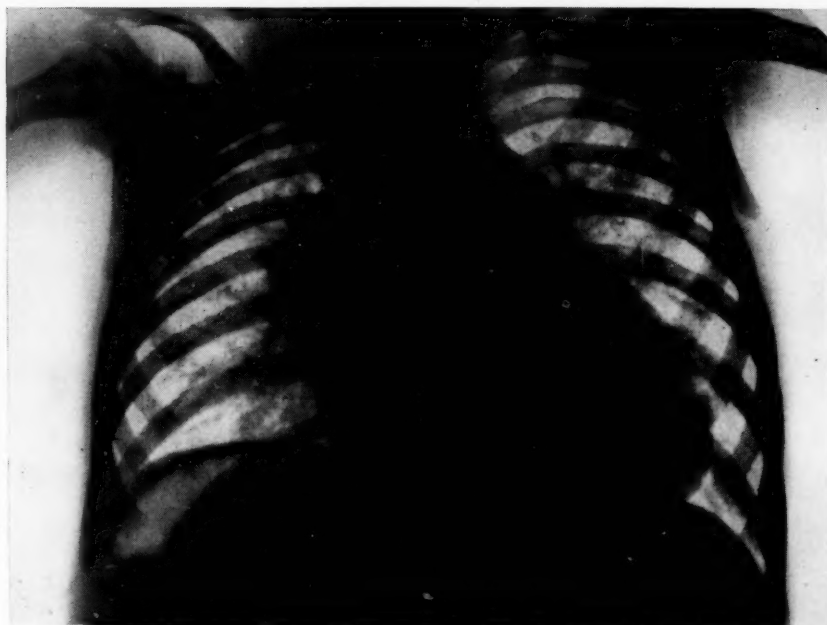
Case 2: radiograph showing heart in normal position with enlarged pulmonary conus, a stomach bubble under the right dome of the diaphragm, and post-pertussis hilar adenopathy on the right.
